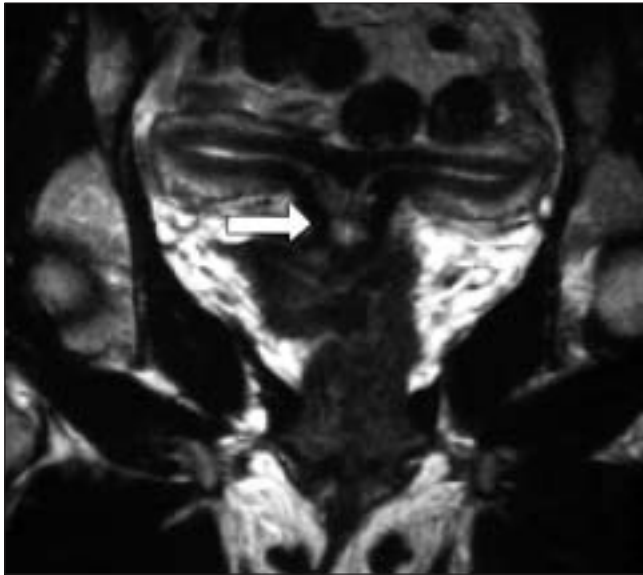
MRI image of bicornuate uterus – (class IV AFS). The arrow indicates the partial fusion of both uterine horns in the lower uterine segment. Note that the angle between both uterine horns is close to 180°.
